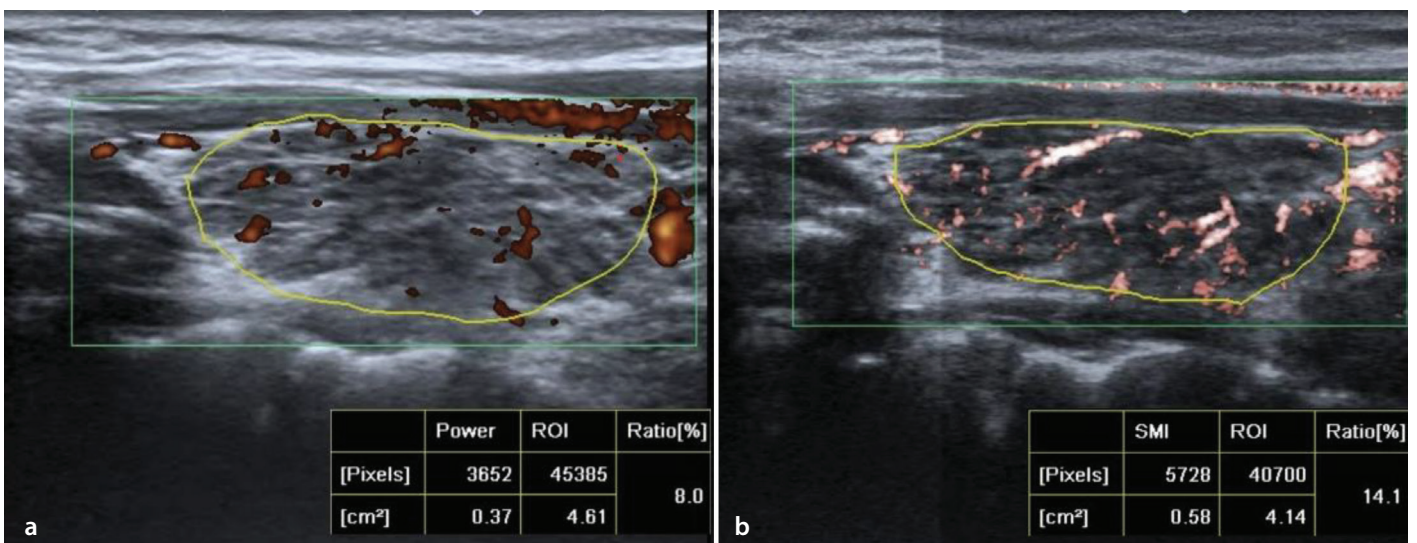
Quantitative vascularity index values were determined by manually tracing the contours of the thyroid gland structure in (a) power Doppler and (b) color superb microvascular imaging mode. The measurements were performed in the longitudinal planes of the right lobe. ROI, region of interest; SMI, superb microvascular imaging.
